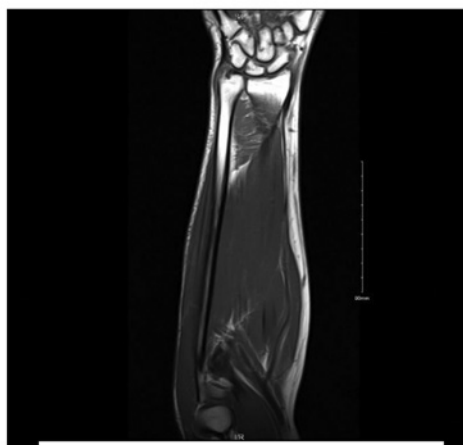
MRI L arm showing subcutaneous oedema
